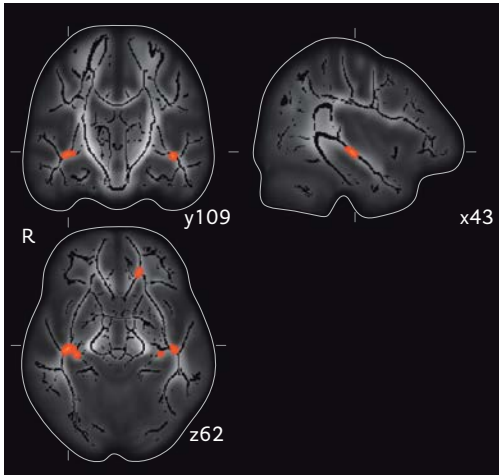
Aging and reduced fractional anisotropy in inferior longitudinal fasciculus. Coronal, sagittal and axial projections of mean fractional anisotropy (FA) MRI image on which the white matter skeleton (black) is projected. MNI coordinates are depicted for each projection. Yellow-to-red colors represent normal-appearing white matter regions with reduced FA in relation to increasing age. When adjusted for global white matter atrophy and white matter lesion volume, only very few regions in the normal-appearing white matter show reduced FA with age, most notably a small region bilateral in the inferior longitudinal fasciculus.
